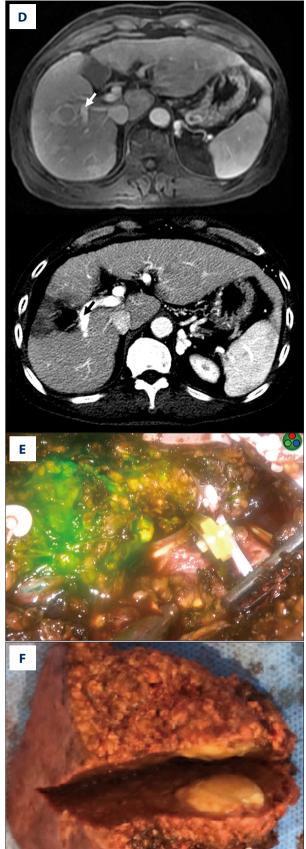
(A) Preoperative magnetic resonance imaging of patient 1 reported 2 irregular tumors adjacent to each other (5.5×5.0 cm in total diameter) at segment 8.
